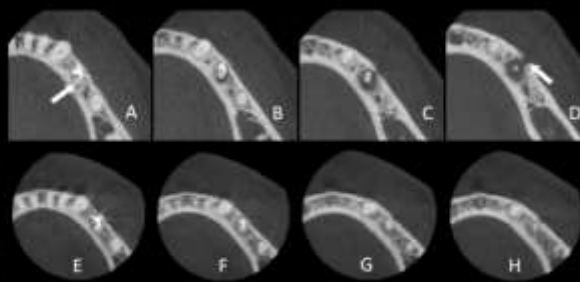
CBCT images. (A to D) preoperative axial images from coronal (A) to apical (D), with presence of a second canal (arrow) in a distolingual position and of an apical lesion in images B to D with buccal fenestration in D (arrow); (E to H) two-years follow-up axial images from coronal (E) to apical (H).
